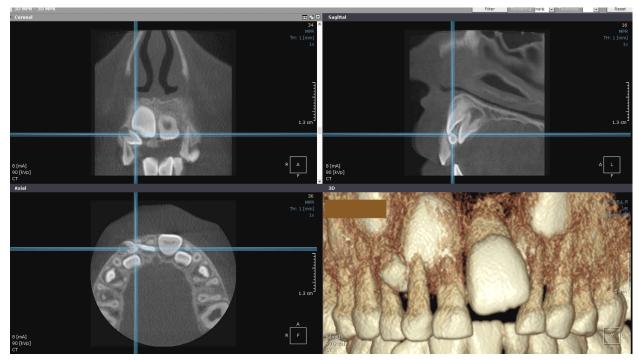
CBCT image offering more details about the position of the supranumerary and clarifying the necessity of its extraction. CBCT: Cone-beam computed tomography.
